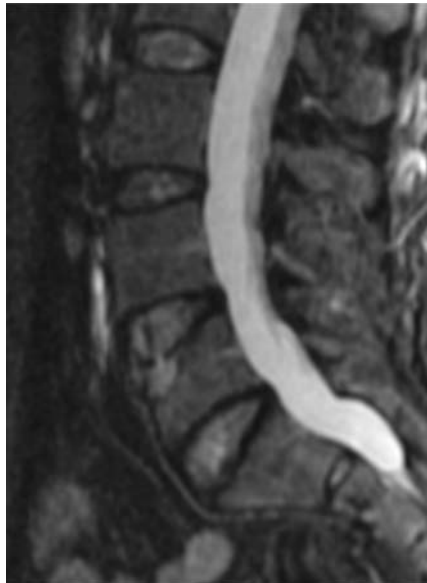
Lumbar MRI performed 9 days following the collision, demonstrating bright signal intensity in the anterior–superior aspect of the L5 vertebral body, consistent with edema and acute fracture.
